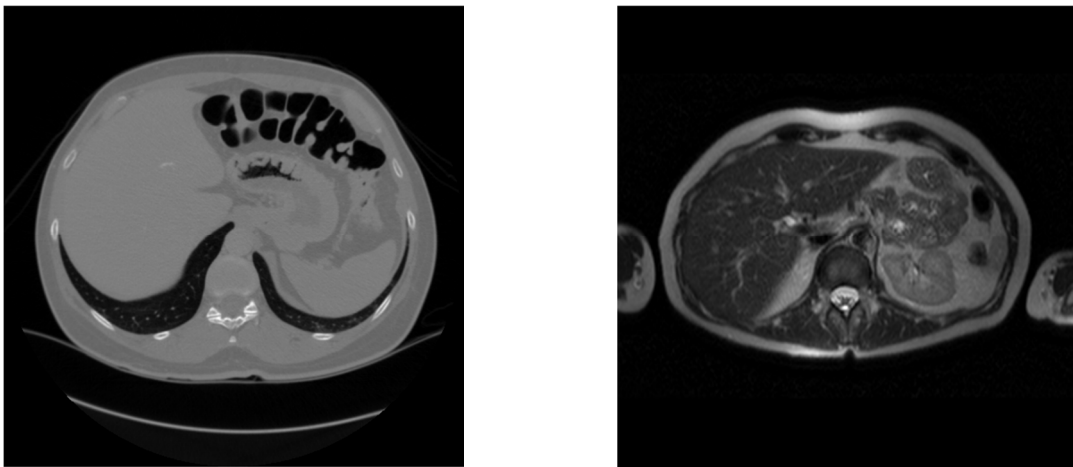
Example of the CT (left) and MRI (right) modality of the used image data
